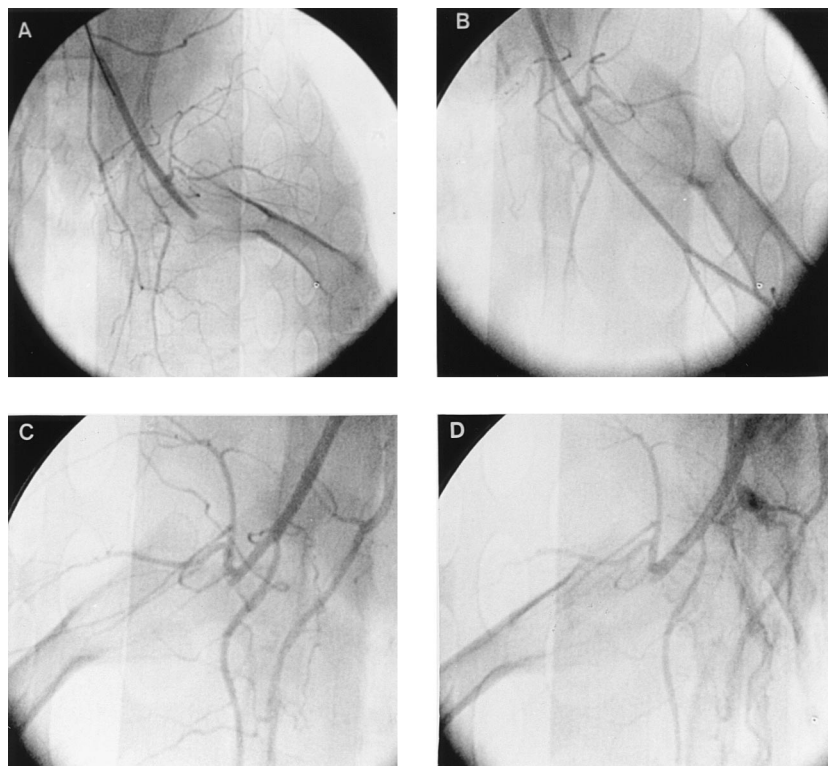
Angiographic example in which the left iliofemoral artery was treated by transcutaneous ultrasound and DDFP. A and C, Baseline angiographic thrombotic occlusions of both iliofemoral arteries. B, Angiogram of the widely patent left iliofemoral artery after 30 min of treatment with transcutaneous ultrasound and DDFP. D, Angiogram of the occluded right iliofemoral artery, which received 60 min of treatment with ultrasound alone.
